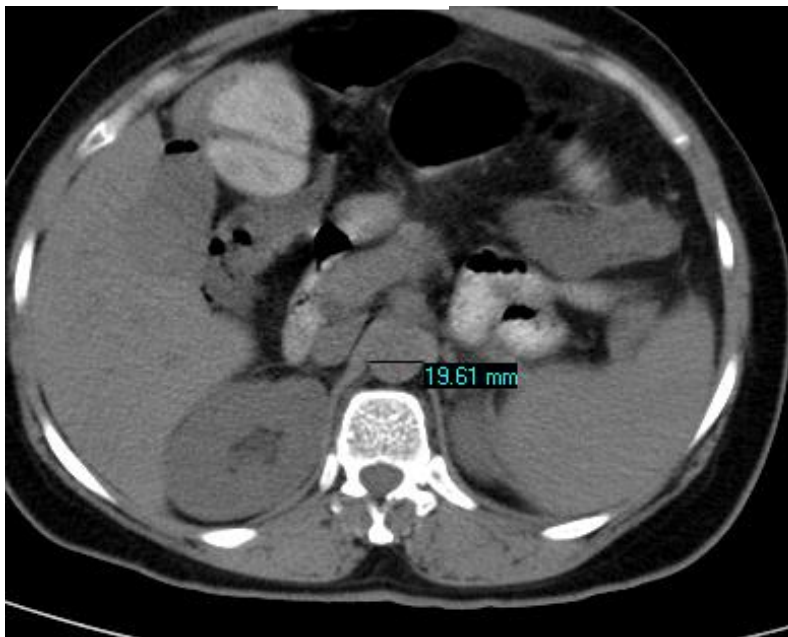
Axial CT Scan image showing the aortic diameters measurements of 43 years old female at T12 level
